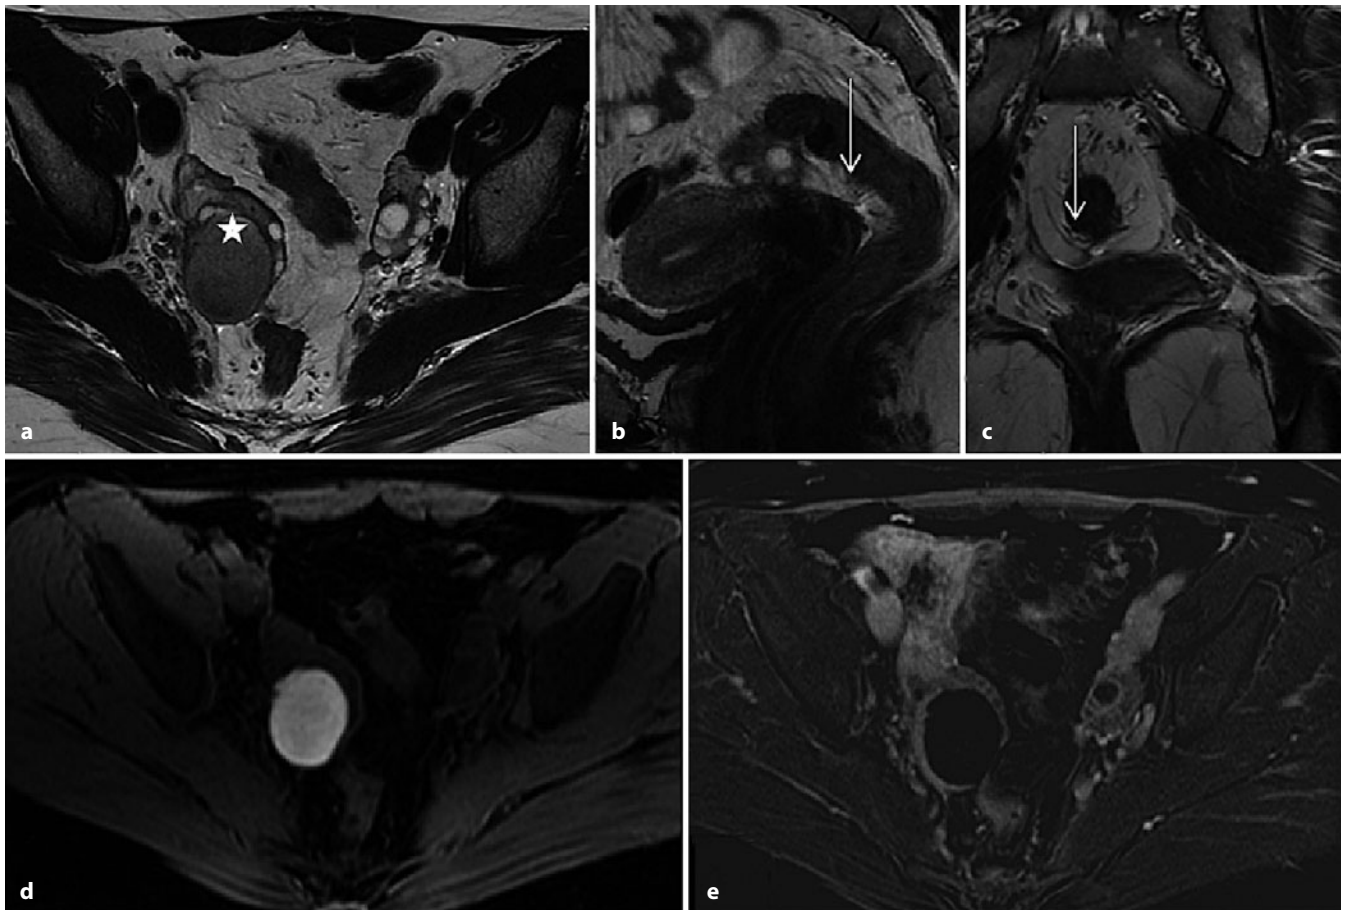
a-e. Ovarian endometrioma. a Axial fast-spin-echo T2-weighted imaging (FSE T2-WI) shows unilocular right cystic ovarian lesion (*asterisk*) demonstrating diffuse hypointensity (i.e., shading effect) relating to chronic hemorrhage. b Sagittal and c coronal T2-WI show some fibrous adhesions in the pouch of Douglas (*arrows*). d Axial fat-suppressed (FS) T1-WI confirms presence of blood product inside the lesion. e Subtraction gadolinium-enhanced FS T1-WI demonstrates absence of mural solid nodules. These findings are suggestive of endometriosis
